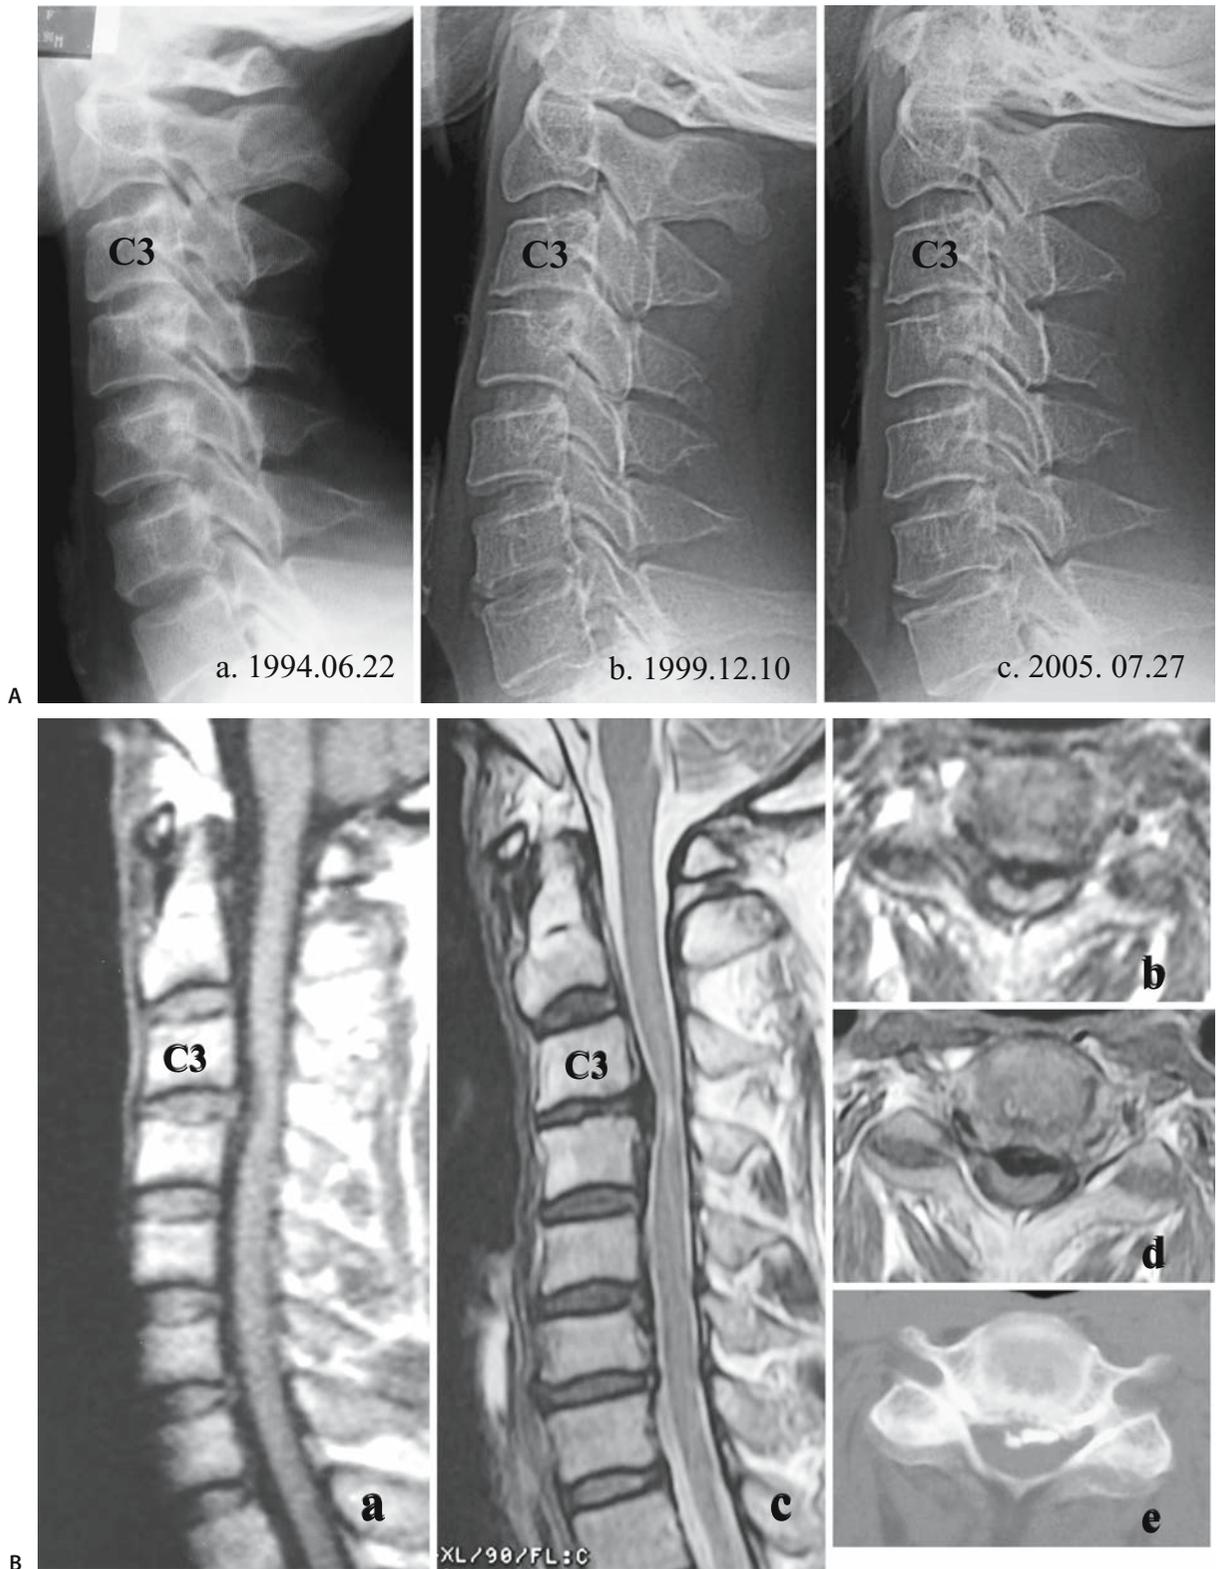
Circumscribed-type OPLL seen at the follow-up of disc herniation in a 42-year-old-man. A, a Plain radiograph shows slight kyphosis in C3-C4 on his first visit to our hospital on June 22, 1994. Radiographs at 5 years 6 months (b) and at 11 years (c) after the first examination show a progressively ossified mass behind the intervertebral disc space at C3-C4.
